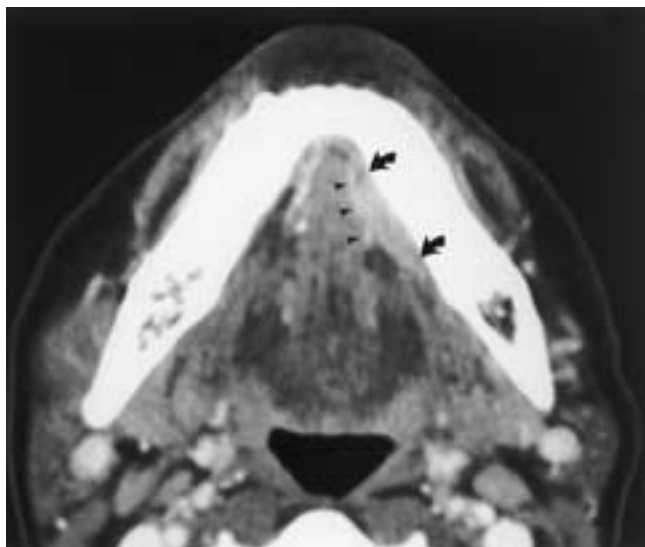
Small squamous cell carcinoma of the floor of the mouth. Axial contrast-enhanced CT scan reveals a small lesion on the left extending along the mylohyoid muscle (*arrows*). There is subtle asymmetry to the sublingual space fat, and the tumor appears to remain lateral to the left neurovascular structures (*arrowheads*). There are no midline displacements. This lesion was initially overlooked.
